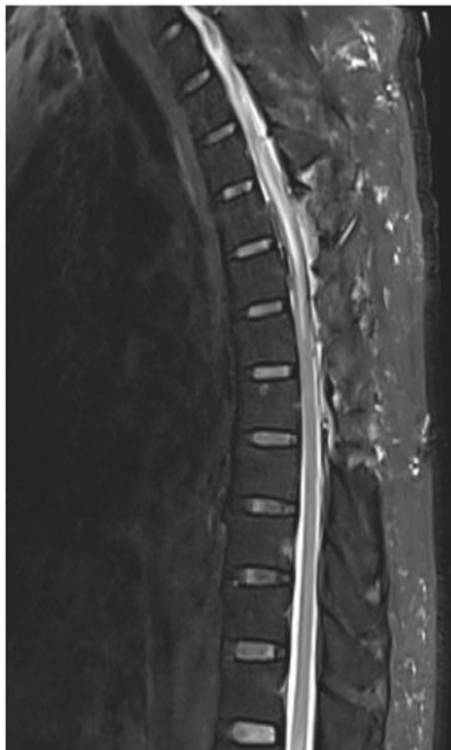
After decompression with hematoma evacuation and laminectomy, thoracic spinal MRI at T4-5 level with sagittal T2-weighted sequence showed a complete clearance of hematoma with normal ventral and dorsal epidural space and resolution of spinal cord compression.
